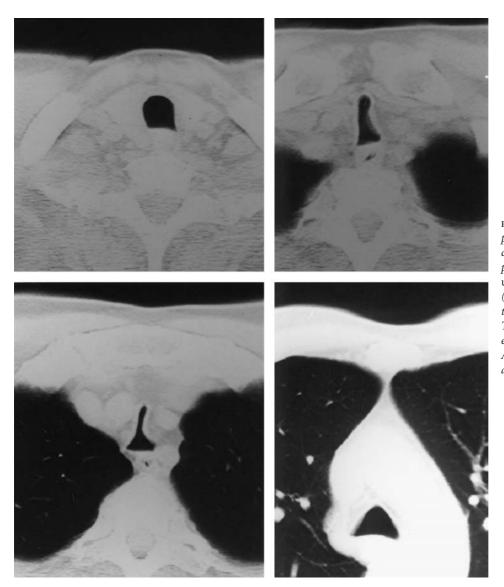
(CONTINUED) B, Computed tomography scans showing changes in tracheal configuration with progression, from the cervical (left upper image), to the upper thoracic (right upper and left lower image), to the lower thoracic (right lower image). The shape of a saber sheath is best exemplified in the right upper image. As the carinal branching is reached, the airway becomes more triangular.
